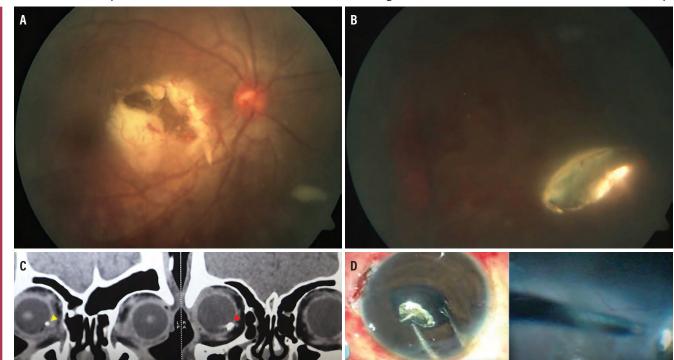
Fundus imaging reveals a large macular tear caused by a high-velocity impact (A). Note the large visible metallic IOFB on the inferonasal retina (B). A second IOFB, hidden in the inferonasal periphery, was localized with the help of a CT scan (C); the CT scan helped to localize the anterior smaller foreign body (left), while the larger foreign body is visible in a posterior scan (right). The larger visible foreign body was brought into the anterior chamber (left), and the smaller anterior foreign body in the periphery was localized with scleral indentation (right) (D).
